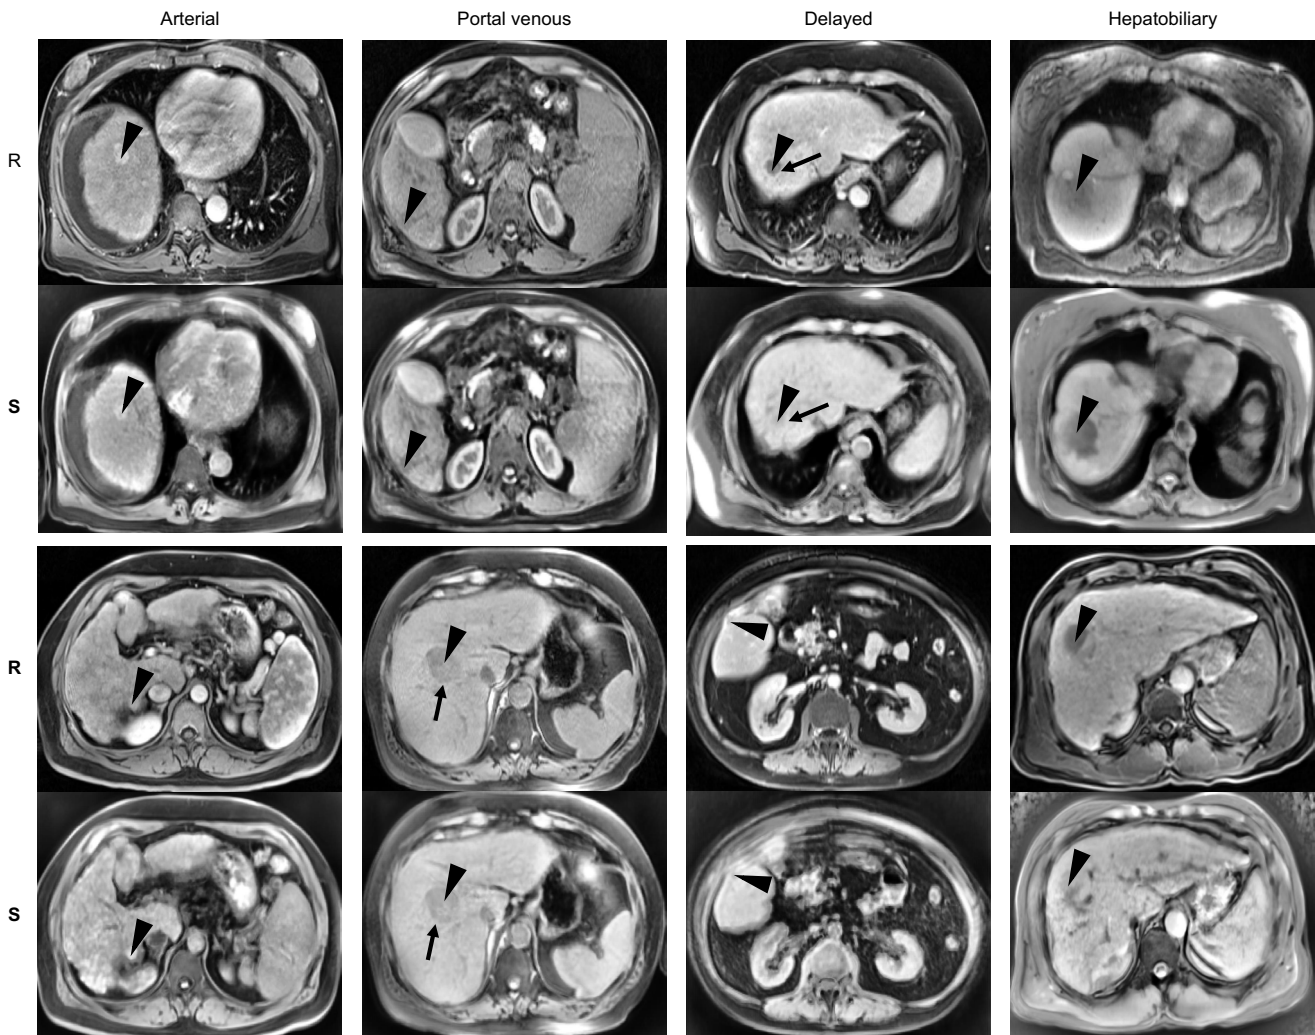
HCC ground-truth and synthetic MRI. Examples are shown of ground-truth (real) (R) and synthetic (S) liver post-contrast MRI phases of patients with HCC, demonstrating LI-RADS features. Both ground-truth and synthetic phases show major LI-RADS features of non-rim arterial hyperenhancement (arrowhead) on the arterial phase, as well as non-peripheral washout (arrowhead) and an enhancing capsule (arrow) surrounding the HCC lesion on the portal venous and/or delayed phases. The ancillary LI-RADS feature of hypointensity on the hepatobiliary phase (arrowhead) is also shown. HCC, hepatocellular carcinoma; LI-RADS: Liver Imaging Reporting and Data System; MRI, magnetic resonance imaging.
